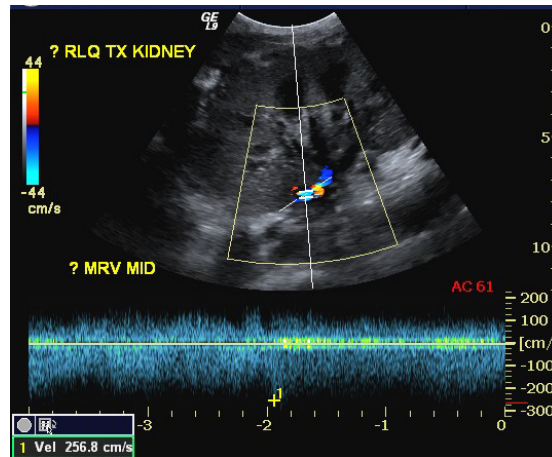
Venous stenosis. Doppler image through the transplant renal vein shows extremely high velocity within the renal vein suggesting stenosis.
